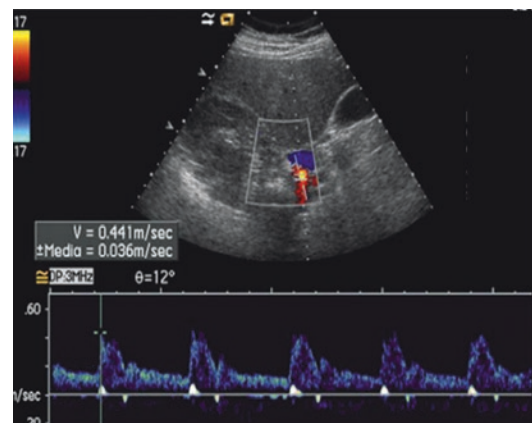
Normal features of the renal artery. Duplex ultrasound image of the right renal artery in a normal subject. At the end of systolic spike is a recognizable small spike called early systolic peak (ESP)
